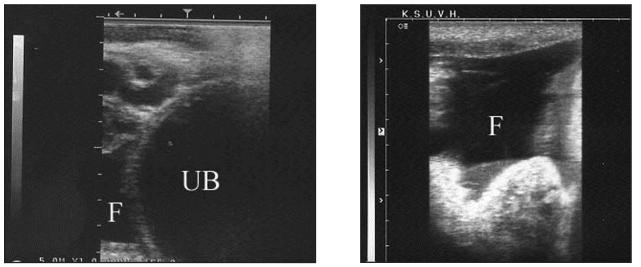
Transrectal ultrasonograms in 2 camels with trypanosomiasis. The intestinal loops and wall of urinary bladder (UB) appeared hyperechogenic and are floating in a anechoic fluid (F).
